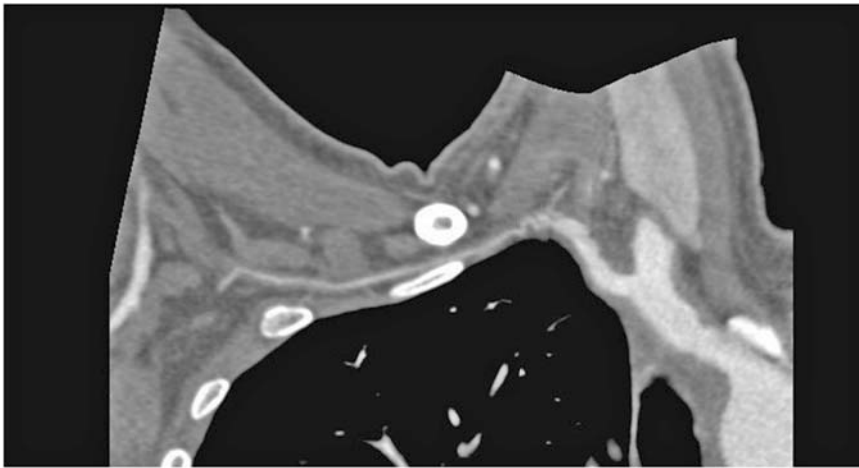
CT showing severe stenosis of right subclavian artery with distal occlusion
